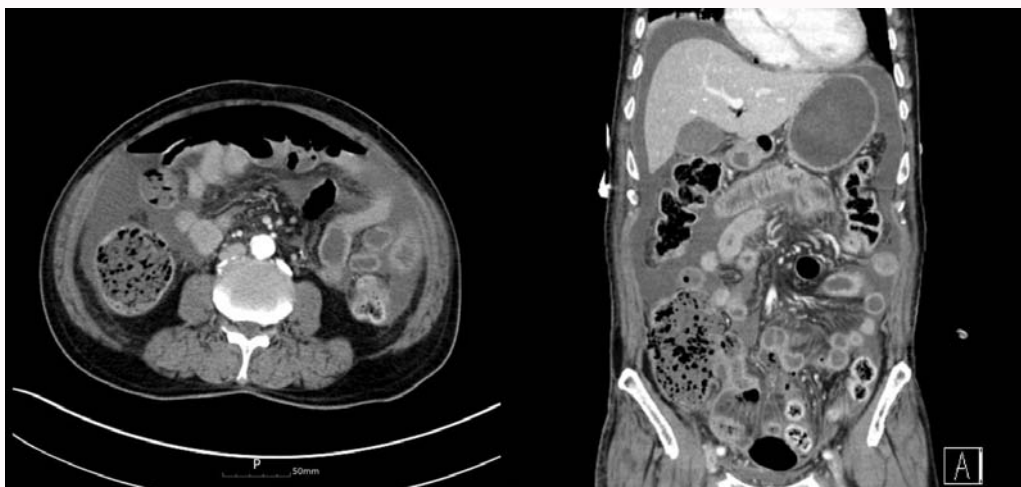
Abdomen CT showed complicated fluid collection and free air in the abdominal cavity.
